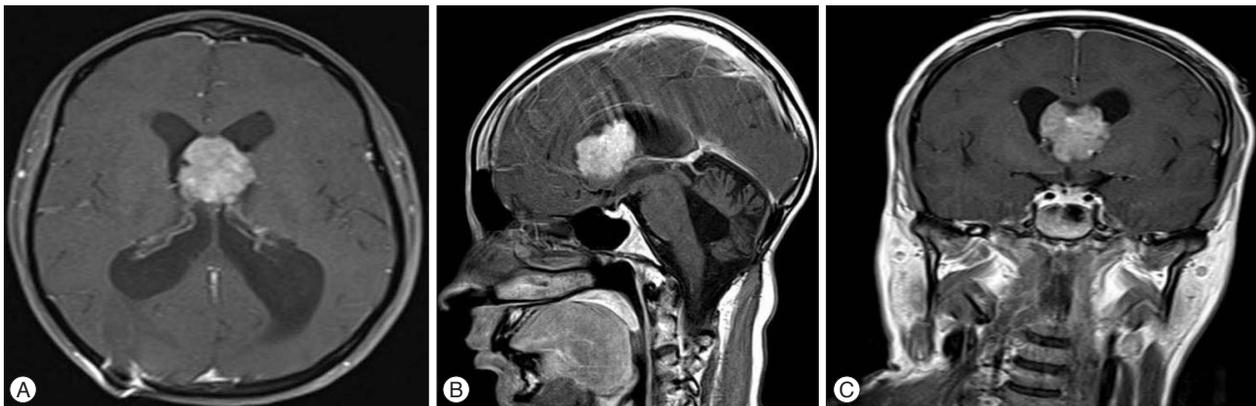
MRI with contrast axial (A), sagittal (B), and coronal (C) showing a homogeneously enhancing septal mass obstructing the foramen Monro.
